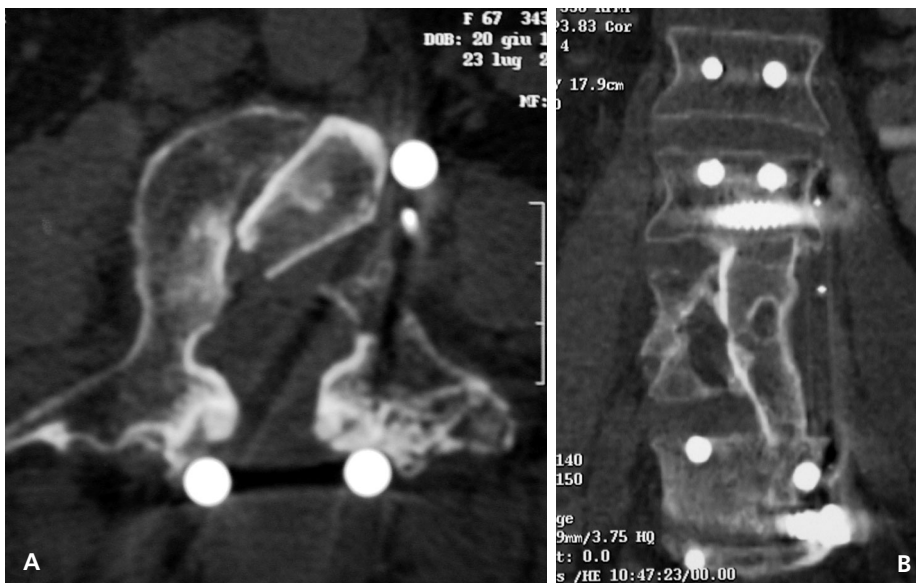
B.A., female, 68 years of age, spondylodiscitis at L3-L4; CT scan for decompression and posterior stabilization, arthrodesis with allograft and plate. A, transverse; B, frontal reconstruction.
